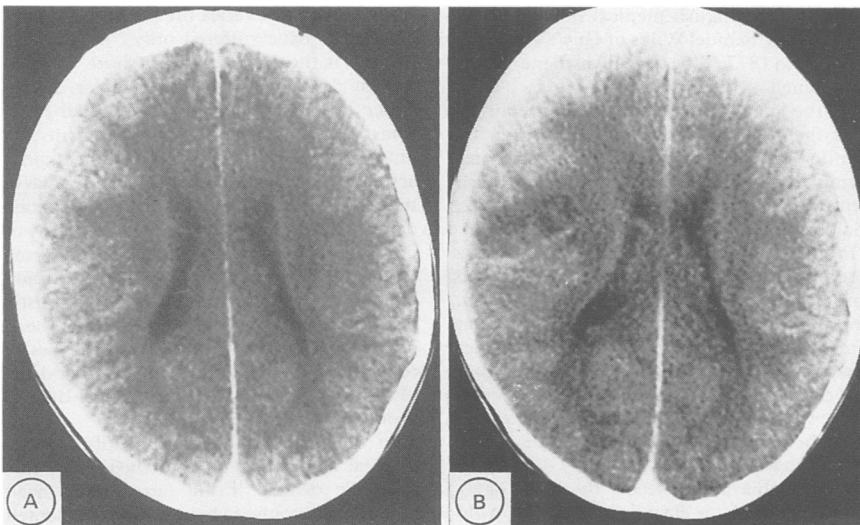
Figure Evolution of the right temporal lesion shown in CT scans; normal scan on day 25, lesion apparent on day 28.
